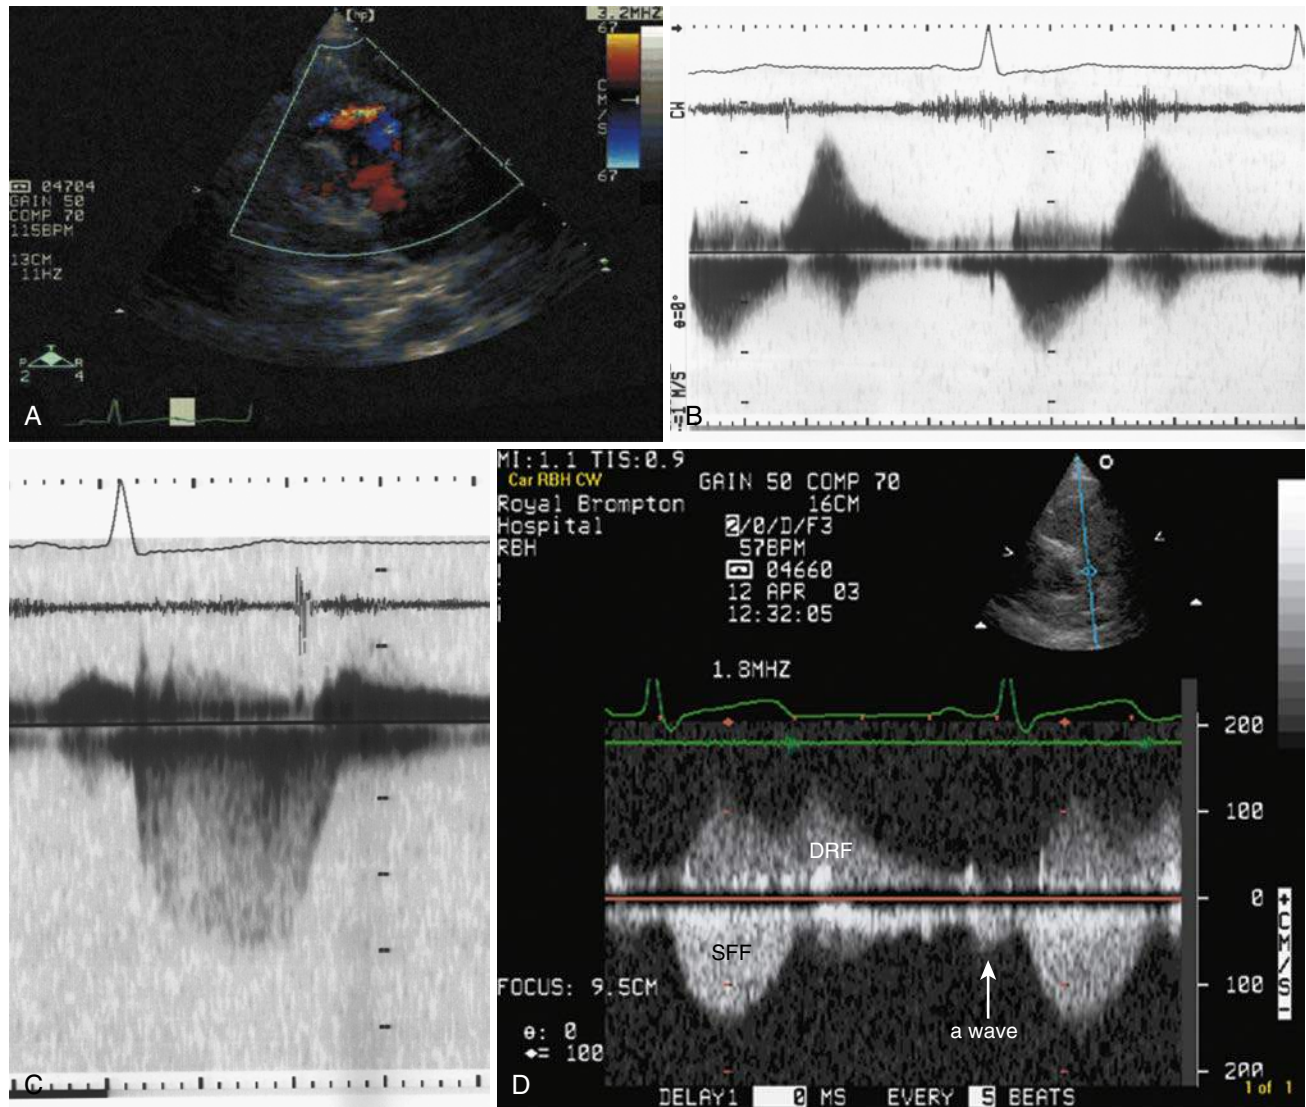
Echocardiographic assessment after repair of tetralogy of Fallot (TOF). A, Color Doppler interrogation of the right ventricular outflow tract (RVOT) in the parasternal short-axis view: patient with free pulmonary regurgitation after previous TOF repair with a transannular patch. Laminar (broad jet) retrograde flow in red from the pulmonary artery in the RV outflow. Note RVOT aneurysm. B, Pulsed-wave Doppler image from the same patient. Note early termination of pulmonary regurgitation (flow above the curve returning to equilibrium by mid-diastole) indicative of severe pulmonary regurgitation. Forward blood velocity is not increased, suggesting the absence of pulmonary stenosis. C, Continuous wave Doppler interrogation of the tricuspid valve from the same patient. Maximum pressure drop across the tricuspid valve is 36 mm Hg, excluding severe proximal or distal pulmonary stenosis. D, Pulsed wave Doppler interrogation of the RVOT in the parasternal short-axis view in a patient with free pulmonary regurgitation (PR) after repair of TOF. As in B, the systolic forward flow (SFF) trace does not demonstrate evidence of pulmonary stenosis and early termination of the diastolic reverse flow (DRF) suggests severe pulmonary regurgitation. There is the additional finding of antegrade flow in late diastole (a wave, arrow) present throughout the respiratory cycle and suggesting so-called RV restrictive physiology. (Courtesy Dr. Wei Li.)
